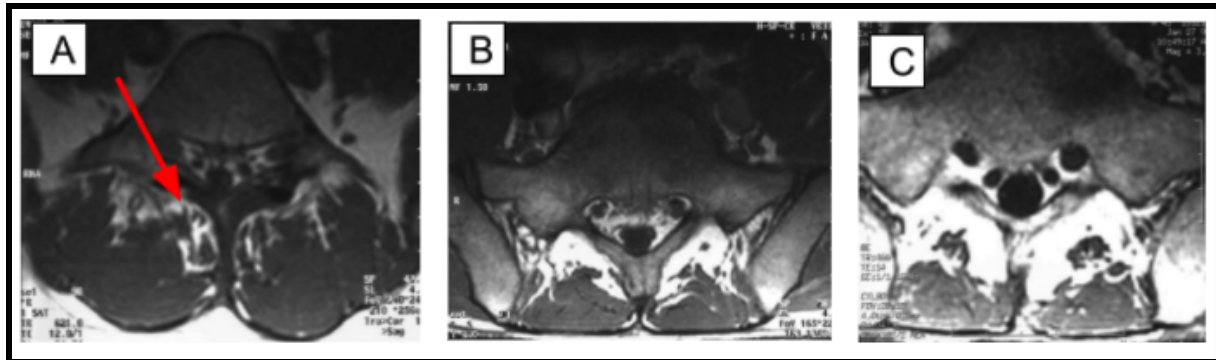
The red arrow is pointing to the white spots within the muscle that are the fat deposits. MRI A shows a mild case of multifidus atrophy. MRI B is a moderate case and MRI C is a severe case of multifidus atrophy.⁸
